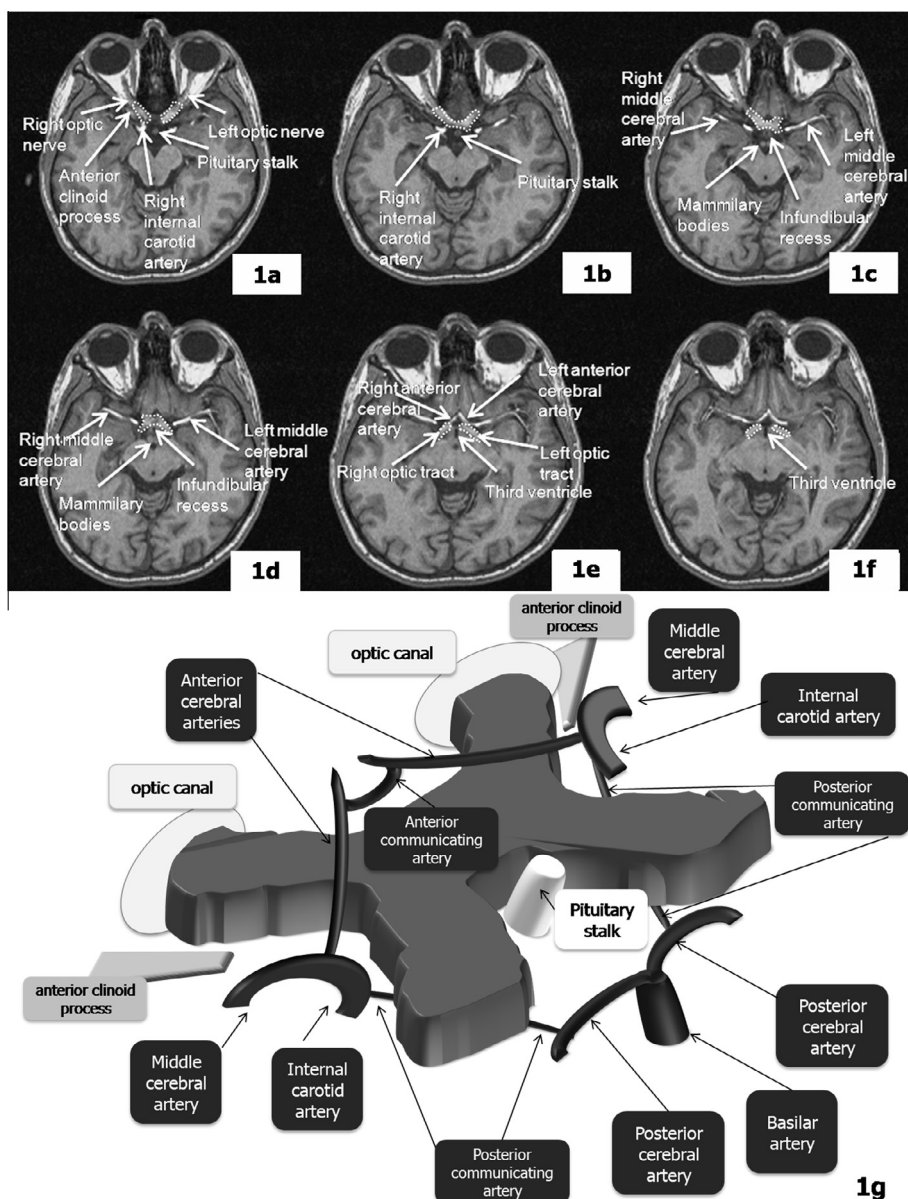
Region of the optic chiasm as it appears on axial T1-weighted MRI scan with contrast. Optic chiasm is contoured as a dotted line. (g) Anatomy of the optic chiasm and its relationship to the circle of Willis.
